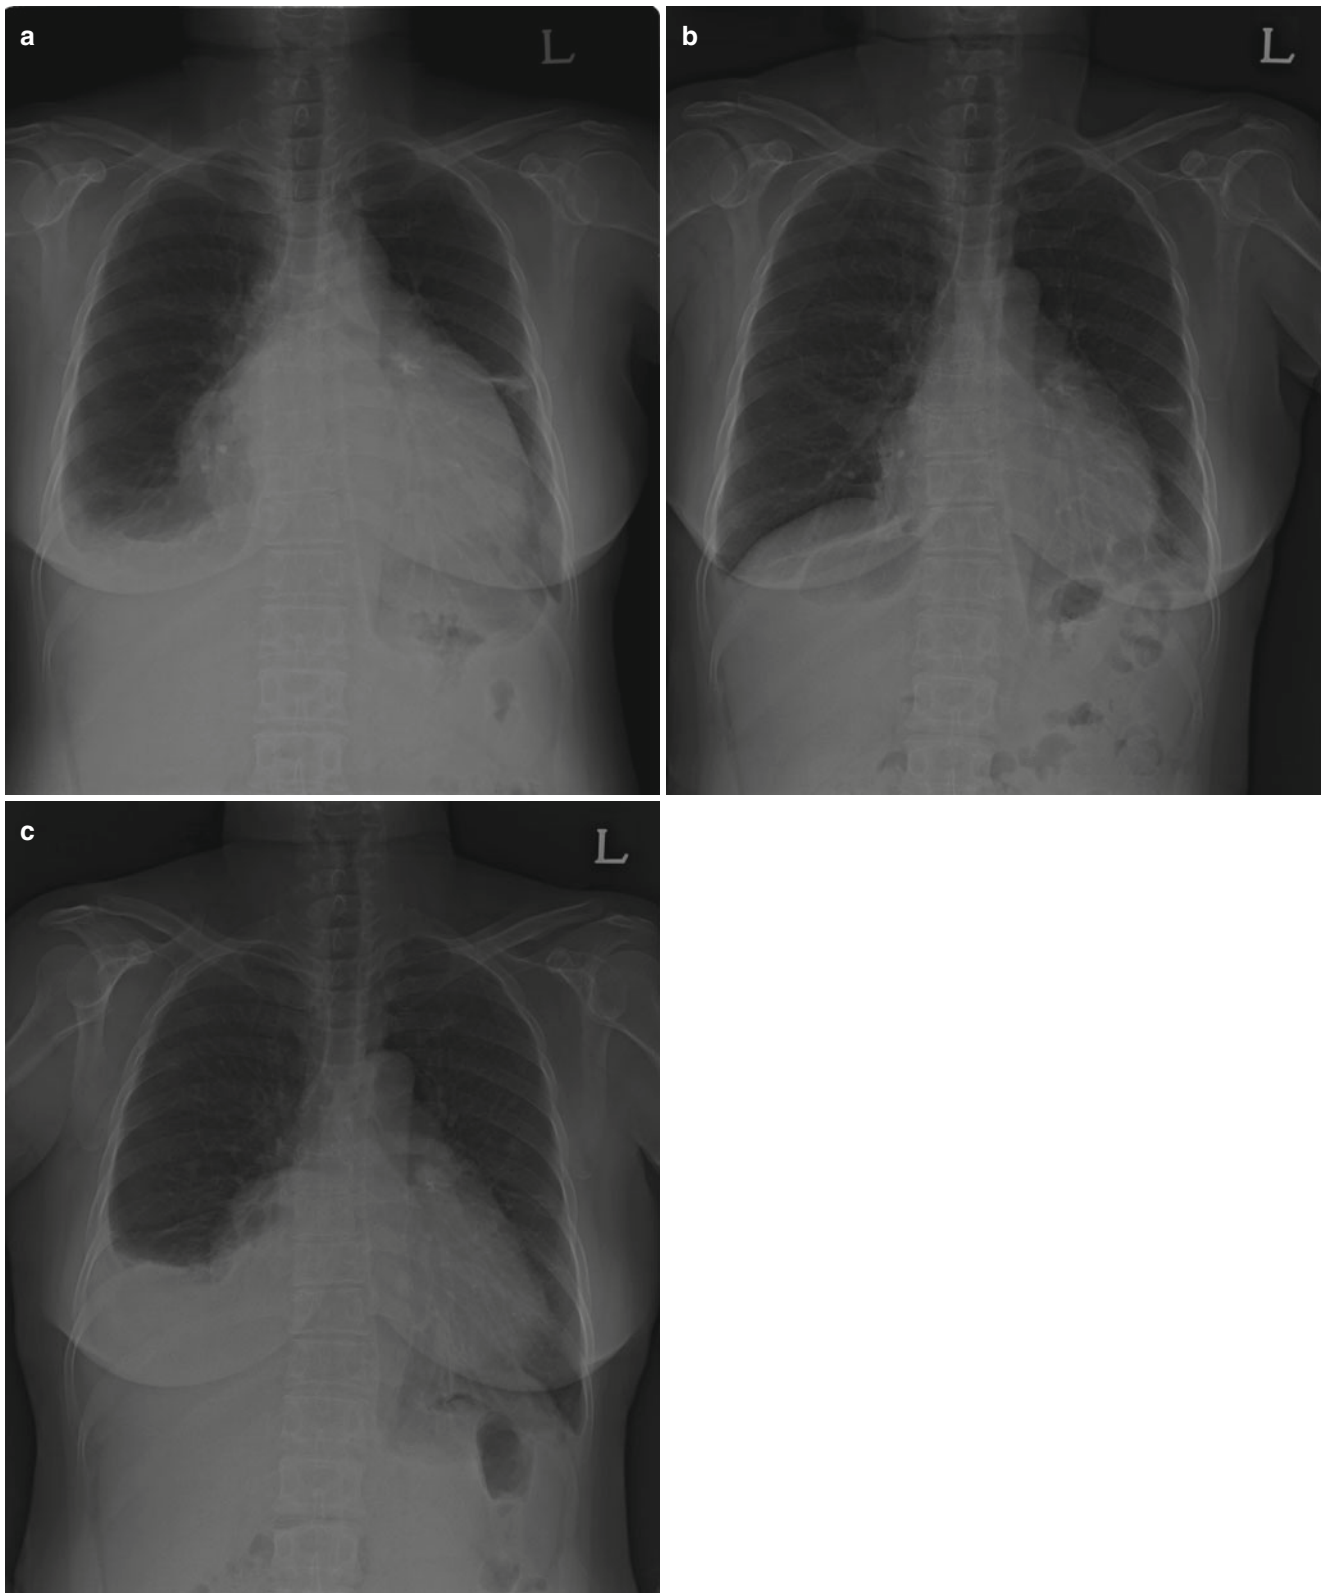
Angiosarcoma initially presented as pericardial effusion. (a) On June 2007, severe cardiomegaly with bilateral pleural effusion and linear atelectasis at the left middle lung zone is seen. (b) One month later, the size of the heart as well as the amount of bilateral pleural effusion is decreased. (c) Another 7 months later, cardiomegaly and bilateral pleural effusion is aggravated. (d) Axial image of CT at the same
